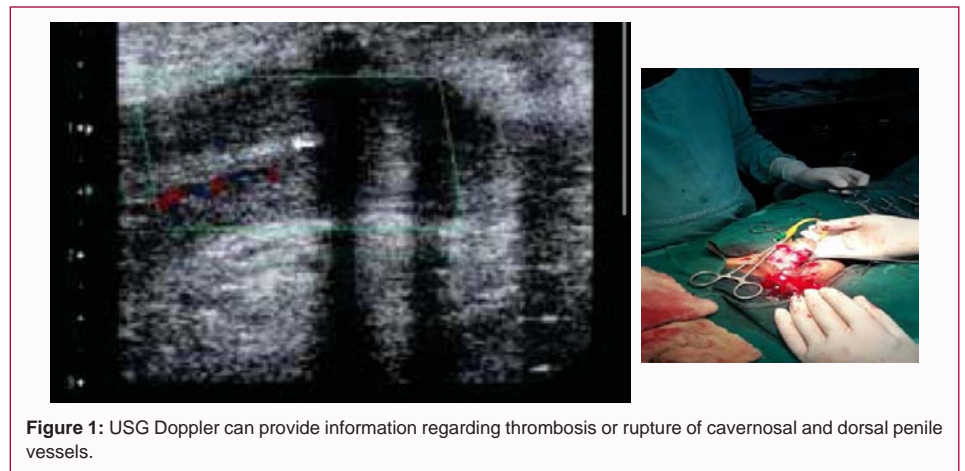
USG Doppler can provide information regarding thrombosis or rupture of cavernosal and dorsal penile vessels.
